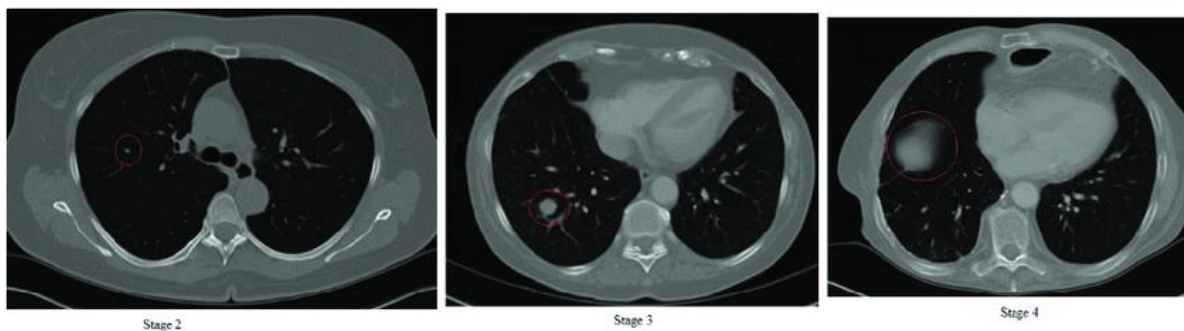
CT scan images of an NSCLC patient through stages 2, 3, and 4 (Jakimovski and Davcev).
